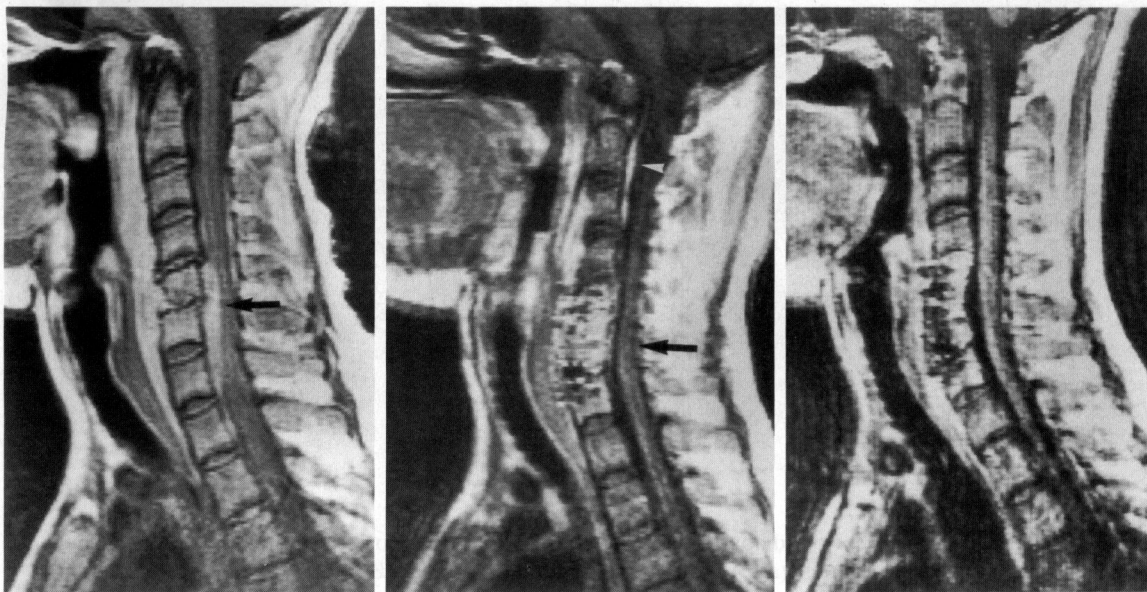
Case 11. A 38-year-old man with a history of intravenous drug abuse developed fever and paraplegia. (a) Postcontrast sagittal T1-weighted image shows a homogeneously enhancing mass in the anterior epidural space, compromising the subarachnoid space and spinal cord at the C-4 to T-1 levels (arrow). There is abnormal alignment of the vertebral bodies and narrowing of the disk spaces at the C-4 to C-6 levels. The patient underwent anterior fusion from C-5 to C-7. Contrast enhancement is noted in the C-5 and C-6 vertebral bodies, indicative of osteomyelitis. (b, c) Postcontrast sagittal (b) and axial (c) T1-weighted images obtained 2 weeks after surgery demonstrate enhancement of the vertebral bodies at the surgical site. Moderate compression of the spinal cord is still observed (arrow in b), and there is engorgement of the anterior epidural veins at the C-2 to C-3 level (arrowhead in b). Circumferential epidural enhancement compromising the subarachnoid space is seen on the axial view (arrows in c). (d, e) Postcontrast sagittal (d) and axial (e) T1-weighted images obtained 4 weeks later show persistent contrast enhancement of the vertebral bodies at the surgical site, but the epidural space is free of abnormal contrast enhancement. The subarachnoid space is clearly visualized. The previously noted engorged epidural veins at the C-2 to C-3 level are no longer visible. The patient was asymptomatic.
